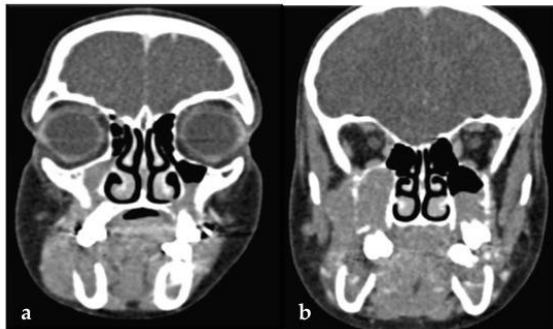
(a,b) CT scans revealing bilateral hypodense soft-tissue lesions occupying the region of the mandibular ramus with superior invasion toward the maxillary sinuses
